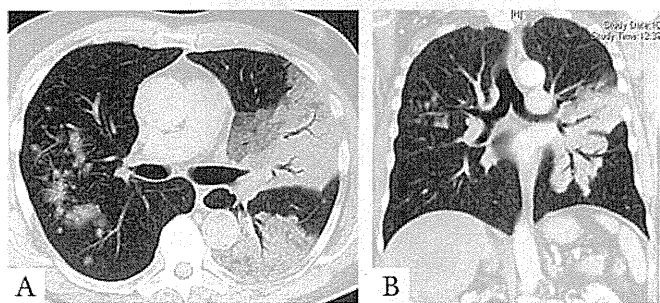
CT of invasive mucinous adenocarcinoma. *A*, Axial and (*B*) coronal CT images show multilobar consolidation and nodules mixed with GGO. Air bronchograms are present. CT, computed tomography; GGO, ground-glass opacity.
